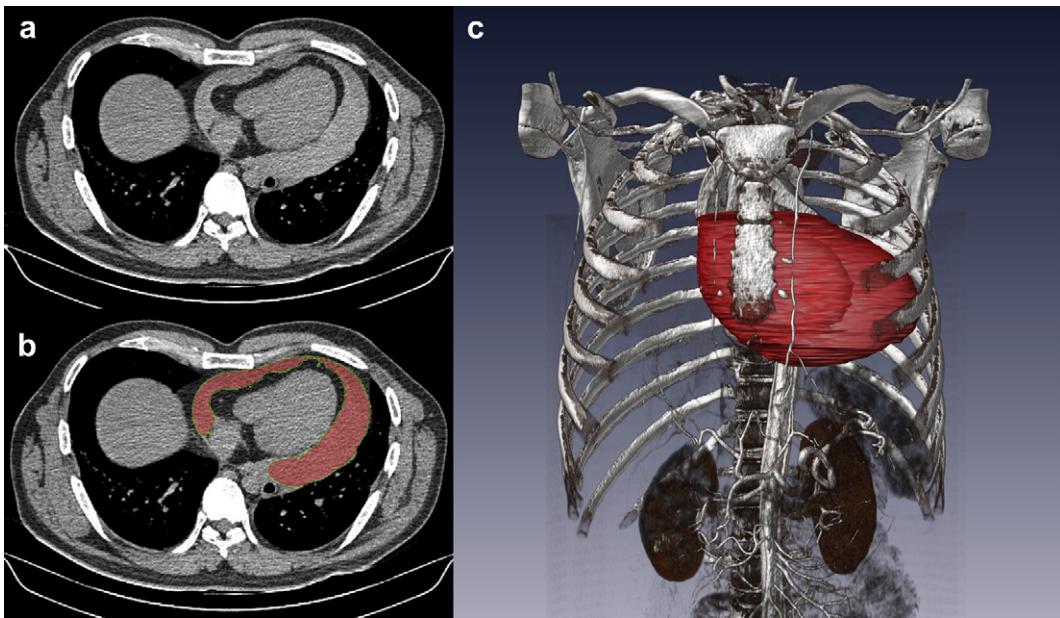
Volume measurement by segmentation using axial CT images (a). A: Pericardial effusion is marked manually for each slice or resampled slices.(b). C.: 3D reconstruction of segmented pericardial effusion.
